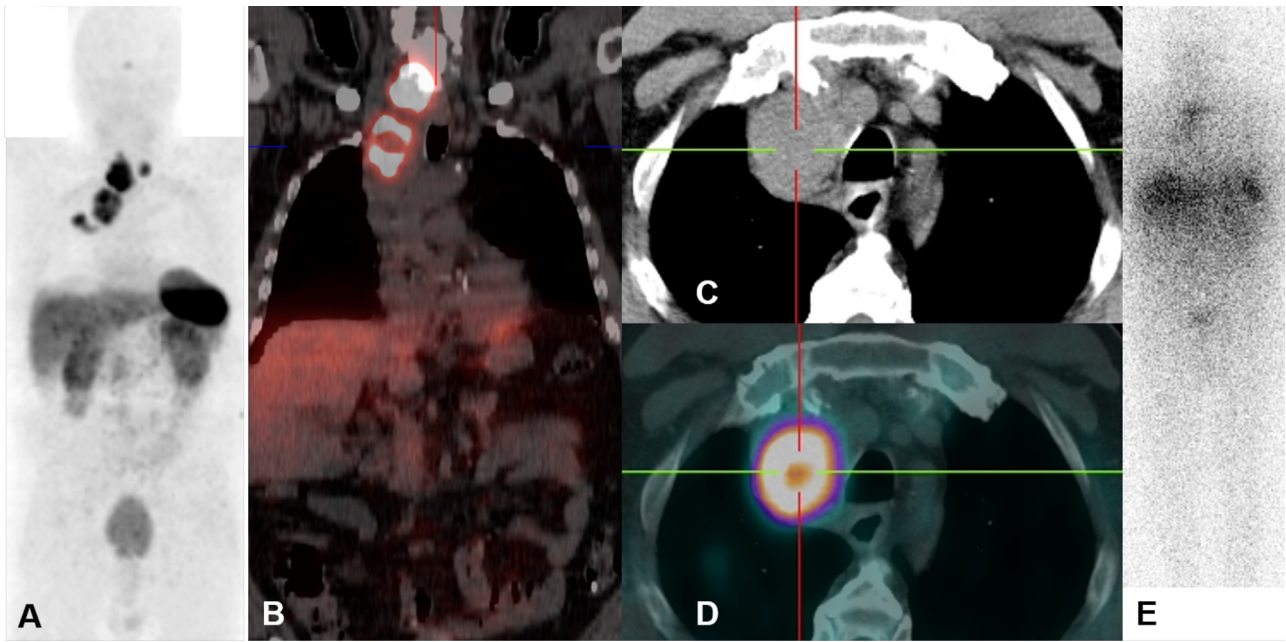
A 65-year-old male with follicular thyroid carcinoma—local recurrent disease with left supraclavicular and large mediastinal lymph node metastasis as well as pulmonary metastasis. The baseline ^{68}Ga -DOTATOC PET/CT (A-D) demonstrated tracer uptake at these sites, also seen on the ^{90}Y -DOTATOC whole-body scan after the first PRRT cycle (E).
